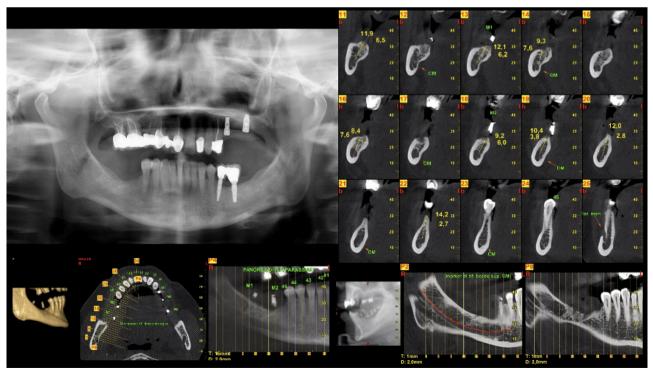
Pre-surgical RX, panorex and CBCT.
